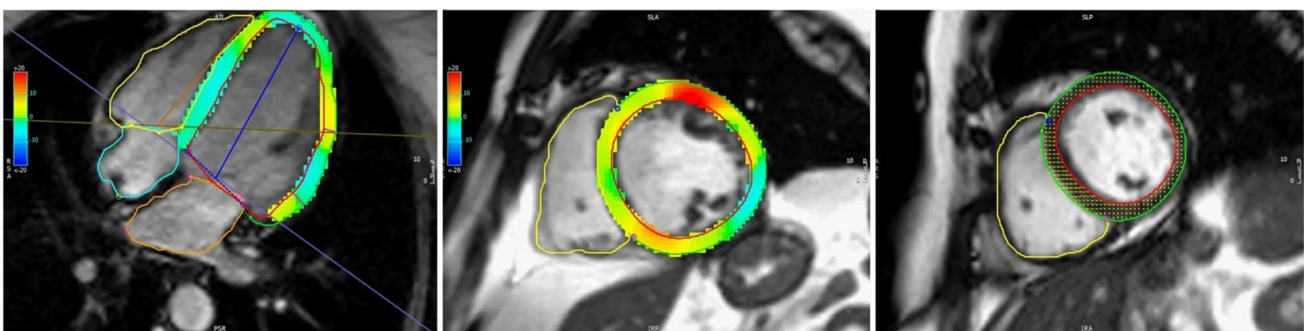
Example of colored 2D strain analysis (apical four chamber view and short axis view) with CMR feature tracking software (Circle CVI42®). On the right column, the endocardial and epicardial
